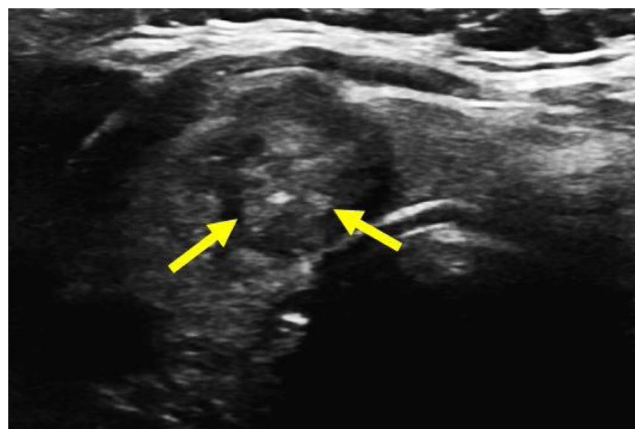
33 year old woman with papillary carcinoma. Transverse ultrasound of the isthmus demonstrating an example of the central echogenic area (arrow) with a non-uniform hypoechoic rim circumferentially around the nodule.
